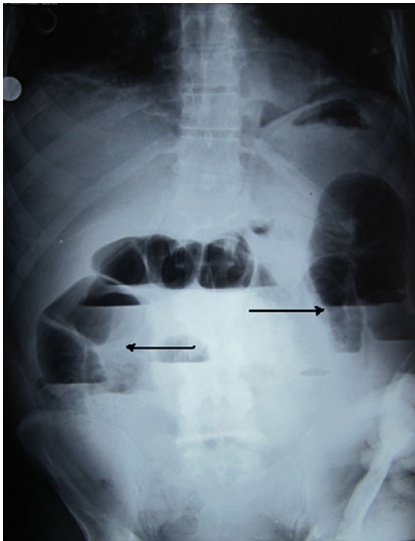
Upright plain abdominal X-ray revealed multiple air-fluid levels (*arrows*)
